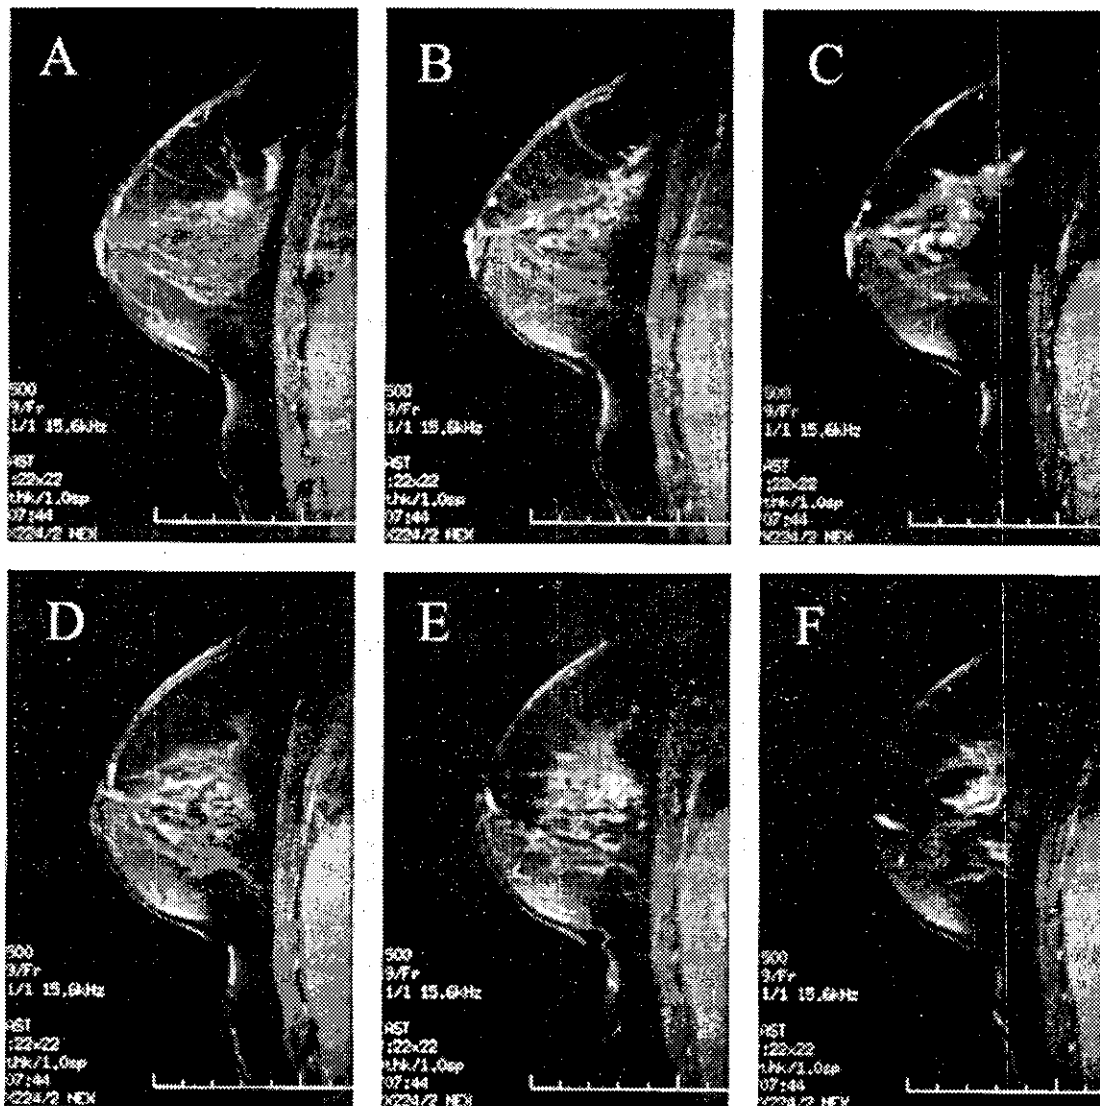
Fat-saturated, contrast-enhanced MRI of the right breast in the sagittal plane. From (A) to (F), a more lateral plane is shown at 6 mm intervals. (A-C) A diffuse segmental enhancement was apparent in the upper quadrant. (D-F) Another segmental enhanced lesion was shown in the lateral quadrant. The scale is graduated in centimeters.
